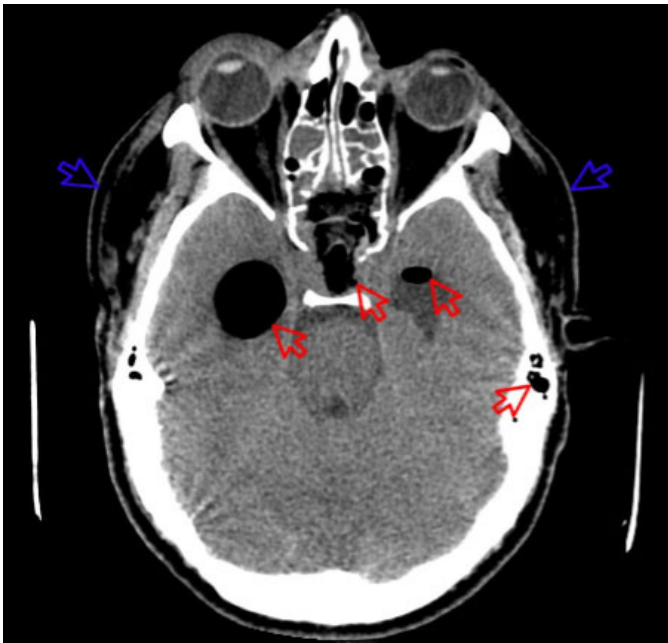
CT scan showing subcutaneous emphysema on the patient head (blue arrows) and persistence of tension pneumocephalus and ventricle (red arrows).
